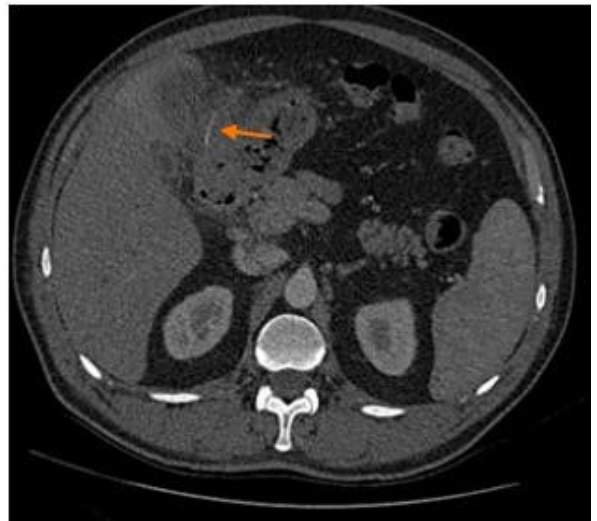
Computed tomography of the abdomen, axial section, in arterial phase, showing a foreign body
